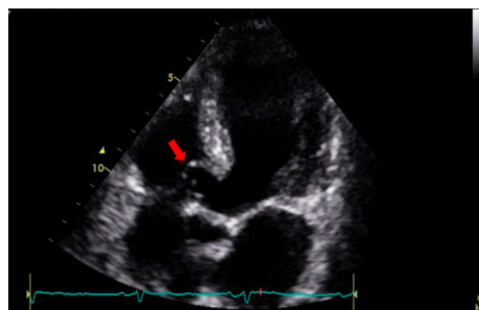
Transthoracic echocardiogram showing a membranous interventricular septal aneurysm (arrow).
